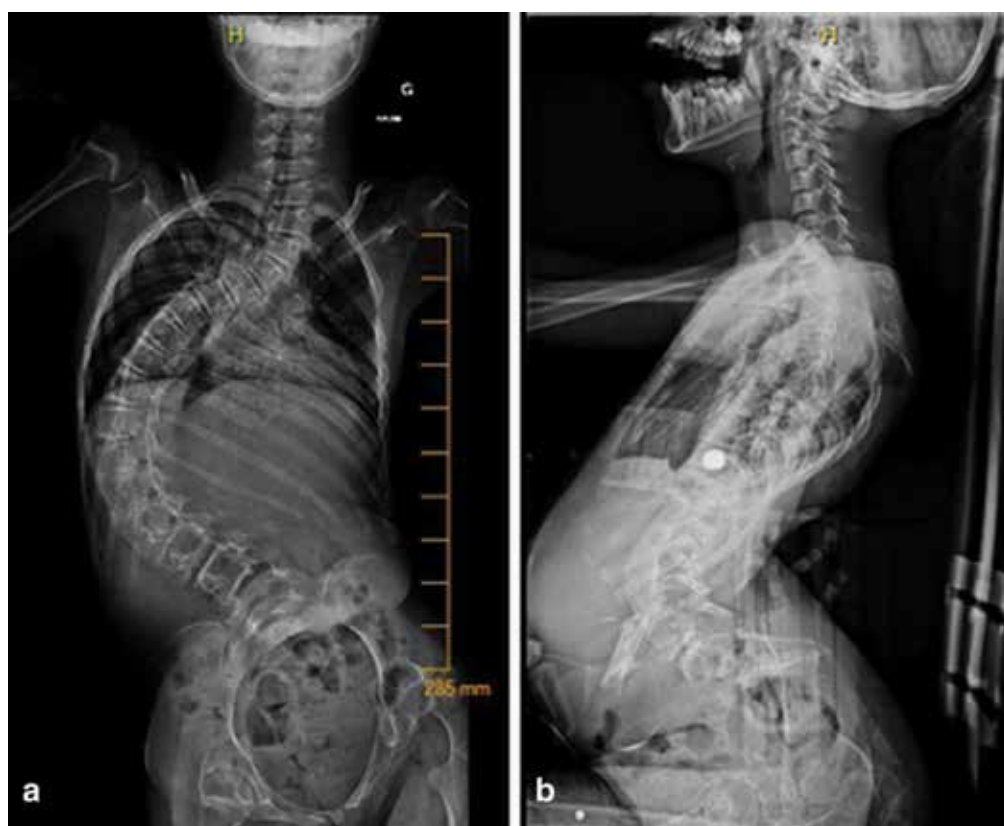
Preoperative anteroposterior radiograph (a) and lateral (b) showing a major thoracolumbar scoliosis with pelvic obliquity.
